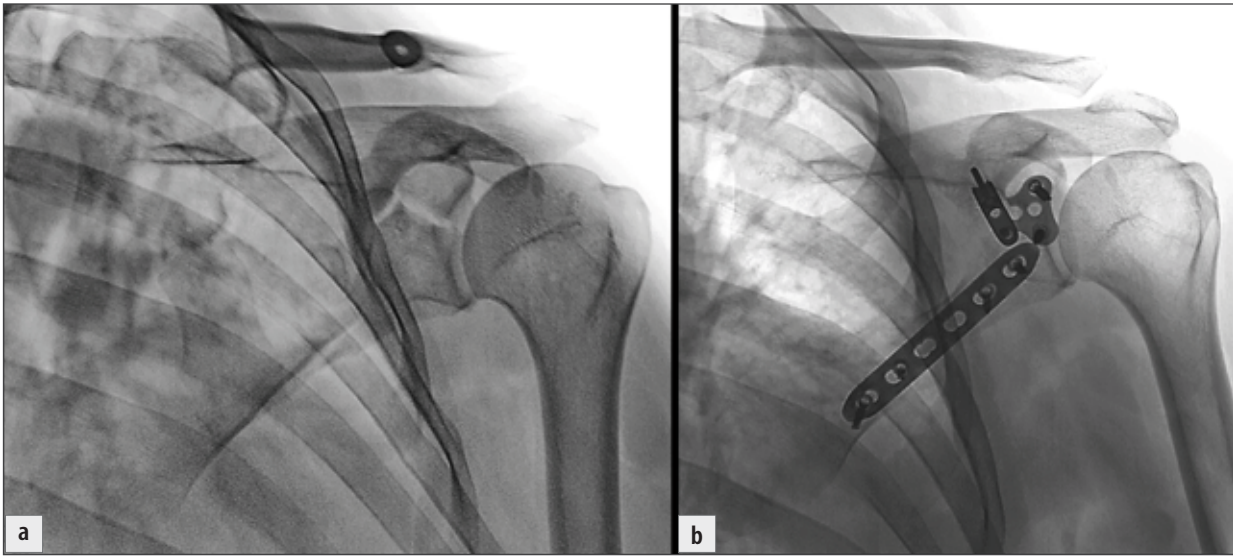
The outcome of reconstruction on radiographs: a) preoperative; b) postoperative.
